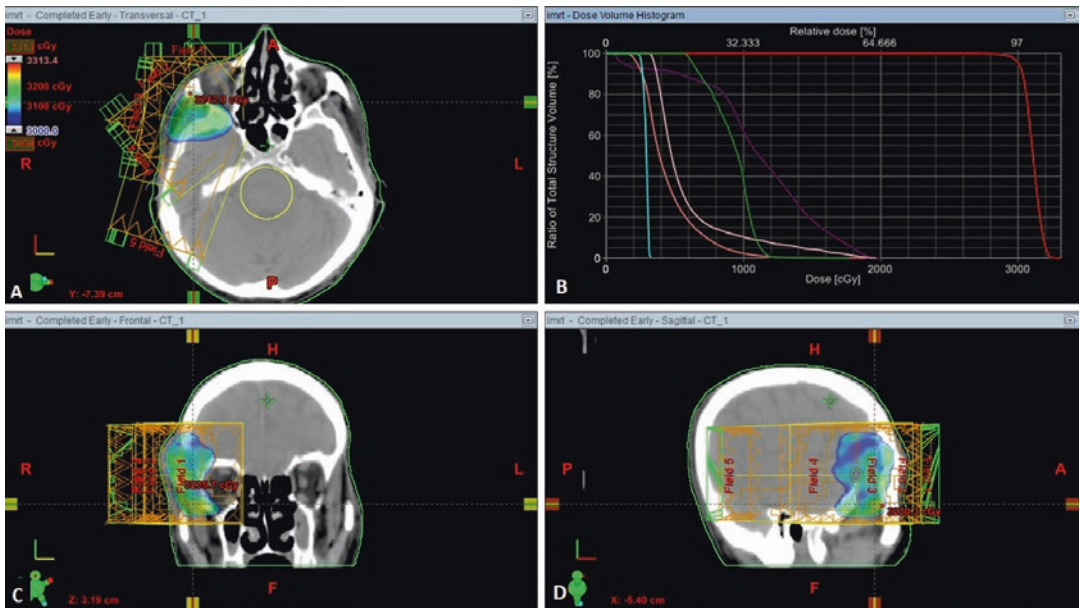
Dose display for IMRT plan. (a) Axial CT with dose color wash. (b) PTV (red), brainstem (purple), right optic nerve (green), optic chiasm (pink), left eye (light
